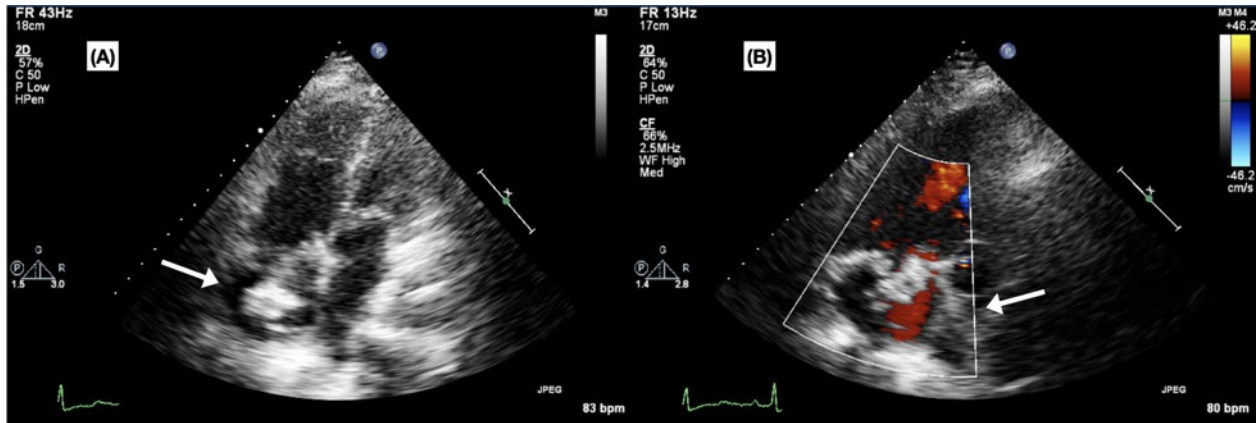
2D Echocardiogram with doppler. (A) A right atrial mass (arrow) is clearly seen. During doppler study (B), there was evidence of regurgitation of blood back into the right atrial (arrow) as highlighted by the red color overlay. This is highly suggestive of tricuspid regurgitation as it occurs during the QRS complex (green line) when the ventricles are contracting.
